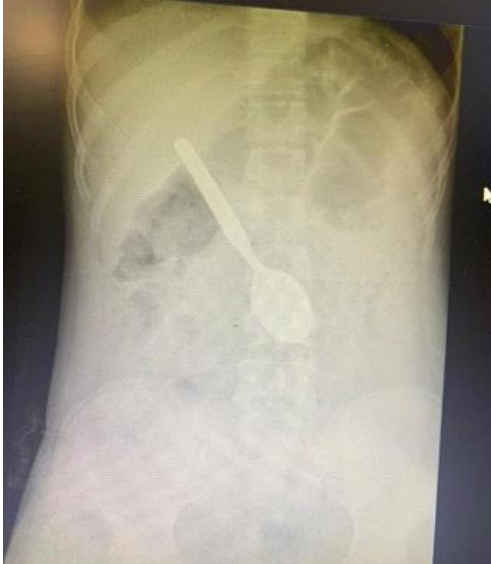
Patients first X-ray taken with the spoon visible
